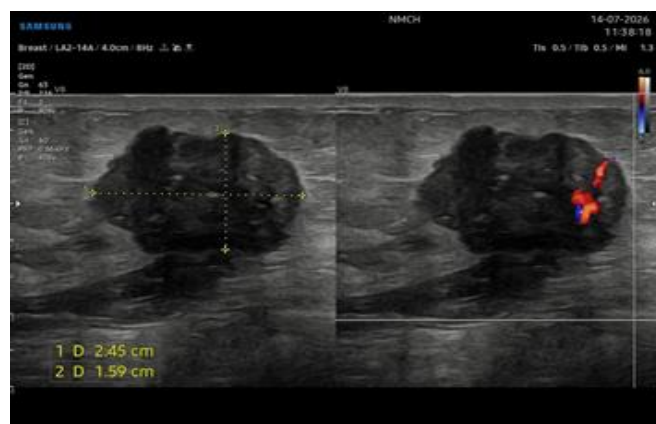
Gray-scale ultrasonography (left) and color Doppler (right) demonstrating an irregular heterogeneously hypoechoic left breast mass with posterior acoustic shadowing and internal vascularity, highly suggestive of malignancy (BI-RADS 5).
